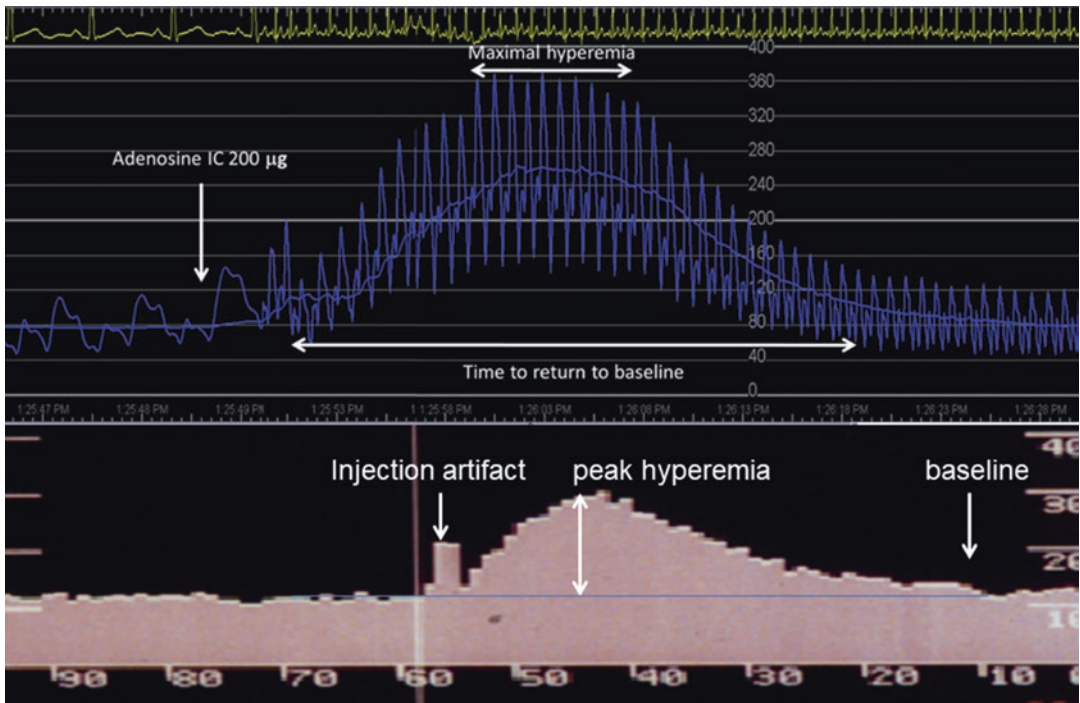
Intracoronary Doppler flow velocity with intracoronary adenosine. *Top*, zero cross Doppler signal showing the maximal hyperemic response after 200mcg adenosine injected intracoronary (IC). Adapted from
